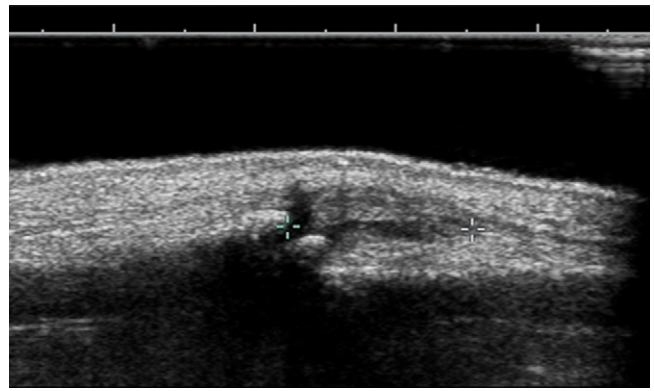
Sagittal dorsal high-frequency ultrasound image showing lengthwise measurement of the articular capsule of a proximal interphalangeal (PIP) 3 joint of a 54-years old female patient with hand OA to evaluate the maximum capsule distension. Left side of image is the distal portion of the joint.
